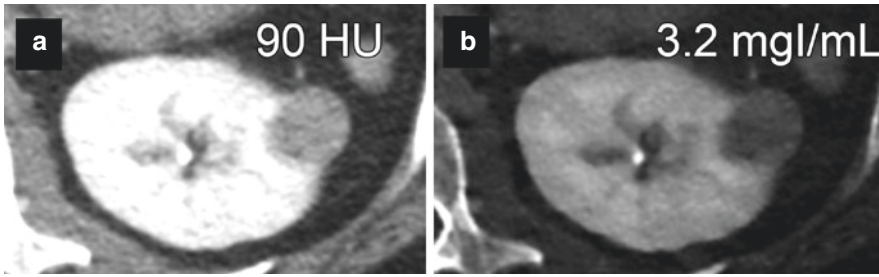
Example of an incidental renal lesion with increased CT attenuation in contrast-enhanced portal-venous phase DECT (a). In SECT, further imaging would be required to differentiate between a hemorrhagic cyst
